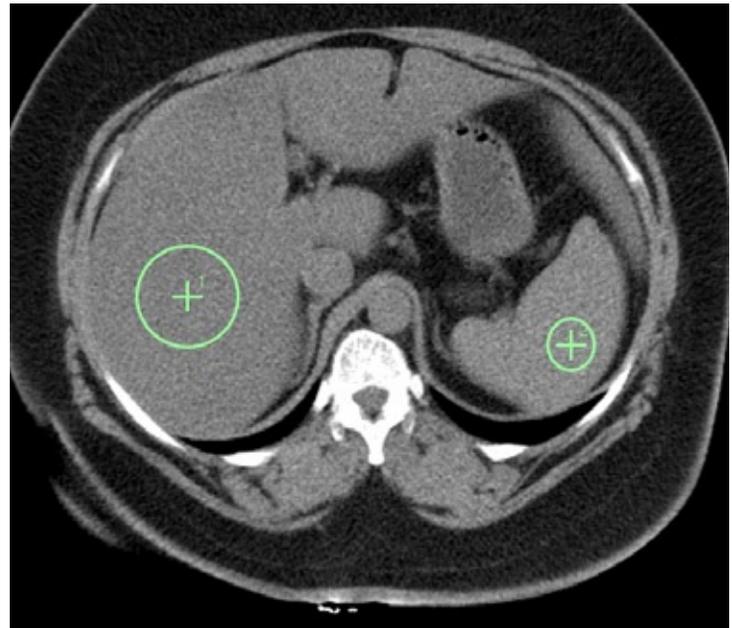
CT without contrast demonstrates liver 41 HU, spleen 56 HU.
